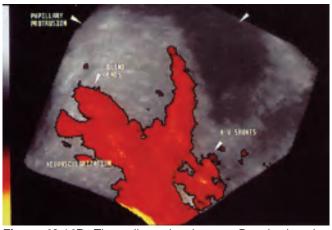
Three-dimensional power Doppler imaging enables evaluation of vascular geometry of the newly formed vessels in a case of fallopian tube carcinoma. Note irregular branching of the vessels, blind-ended lakes and disproportional calibration all indicative for tumoral neovascularization
